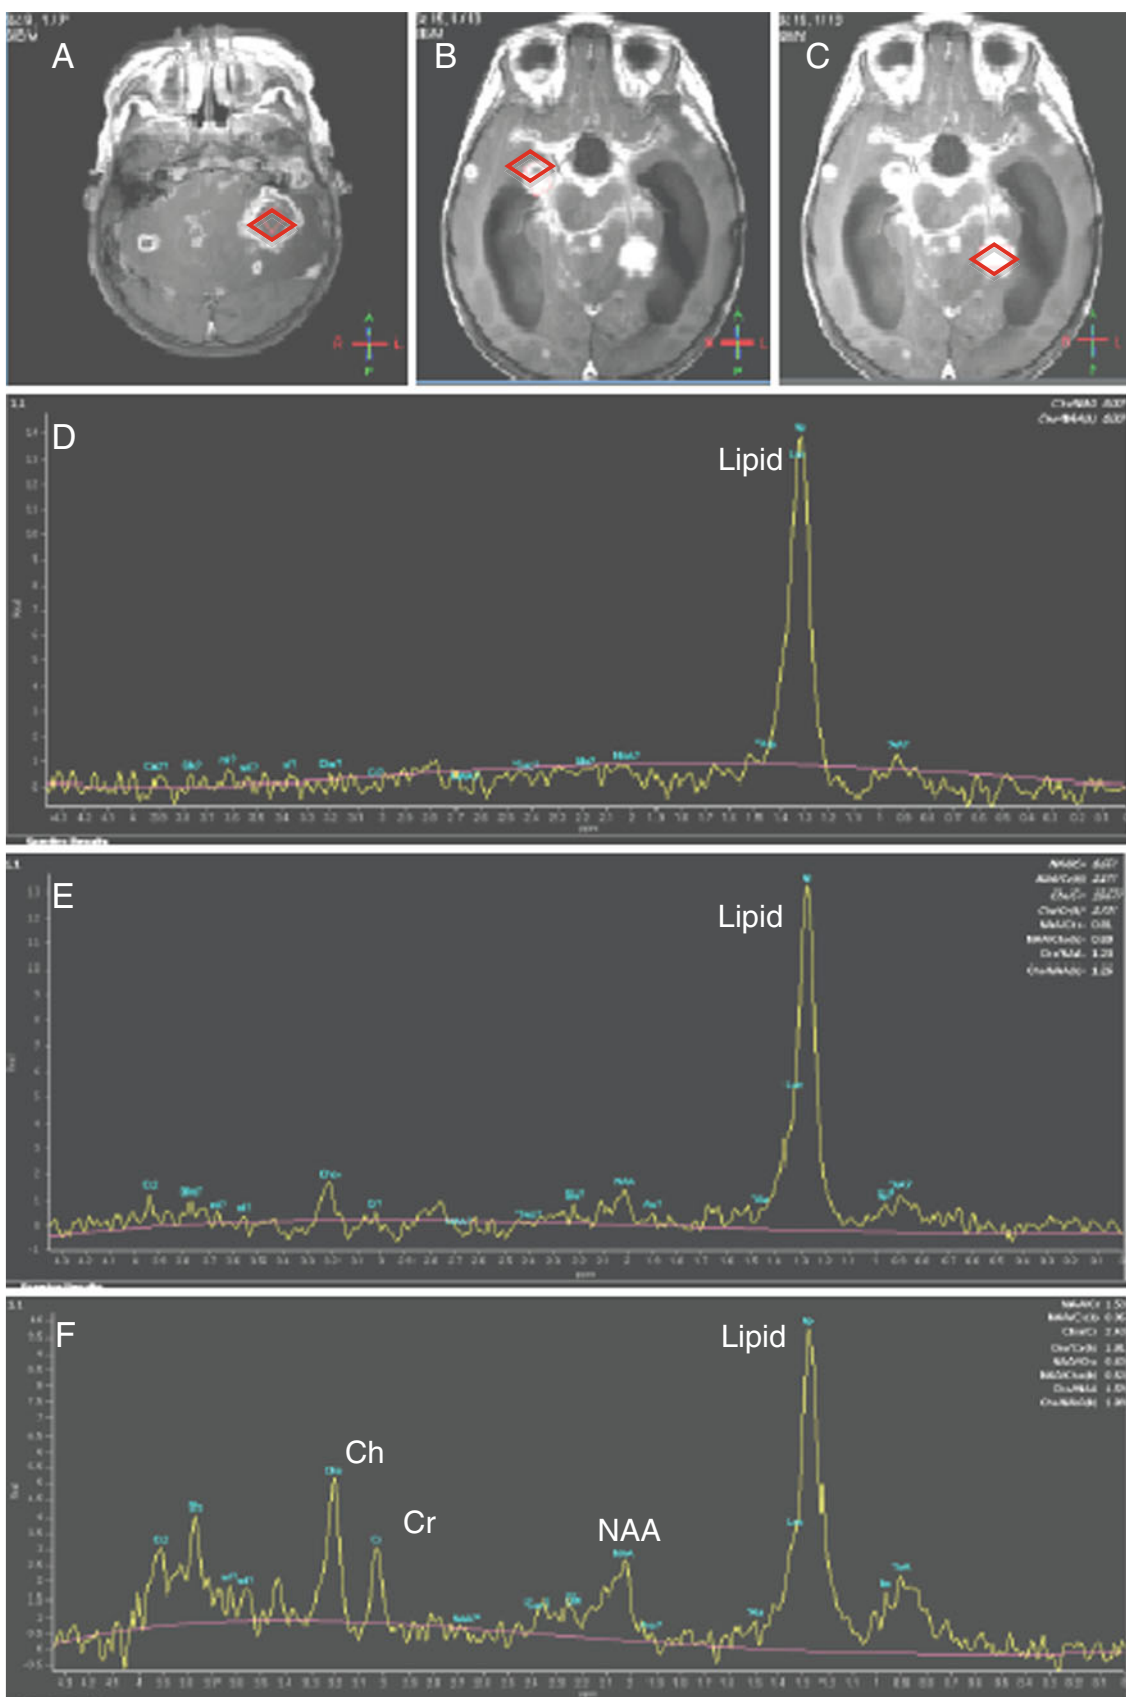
Brain MRI of a 2-year-old boy (case 3) and in vivo $^1\text{H-MRS}$ of three different intracranial lesions. Axial contrast-enhanced T1-weighted images (a–c [identical to b]) show large left cerebellar hyperintense lesion with ring-like enhancement (a) and a smaller right hippocampal lesion (b, c). In addition, a basal contrast-enhancing meningitis is noted suggestive of tuberculous meningitis. $^1\text{H-MRS}$ show increased lipid peaks in the centrally cystic lesion (d, e). The intraparenchymal, hippocampal lesion shows partially maintained cerebral metabolites (N-acetylaspartate [NAA], Creatine [Cr], and Choline [Ch]) next to a large lipid peak compatible with a tuberculoma. The NAA peak is reduced indicating tissue injury (f). Rhombus symbols indicate where the three $^1\text{H-MRS}$ were measured
